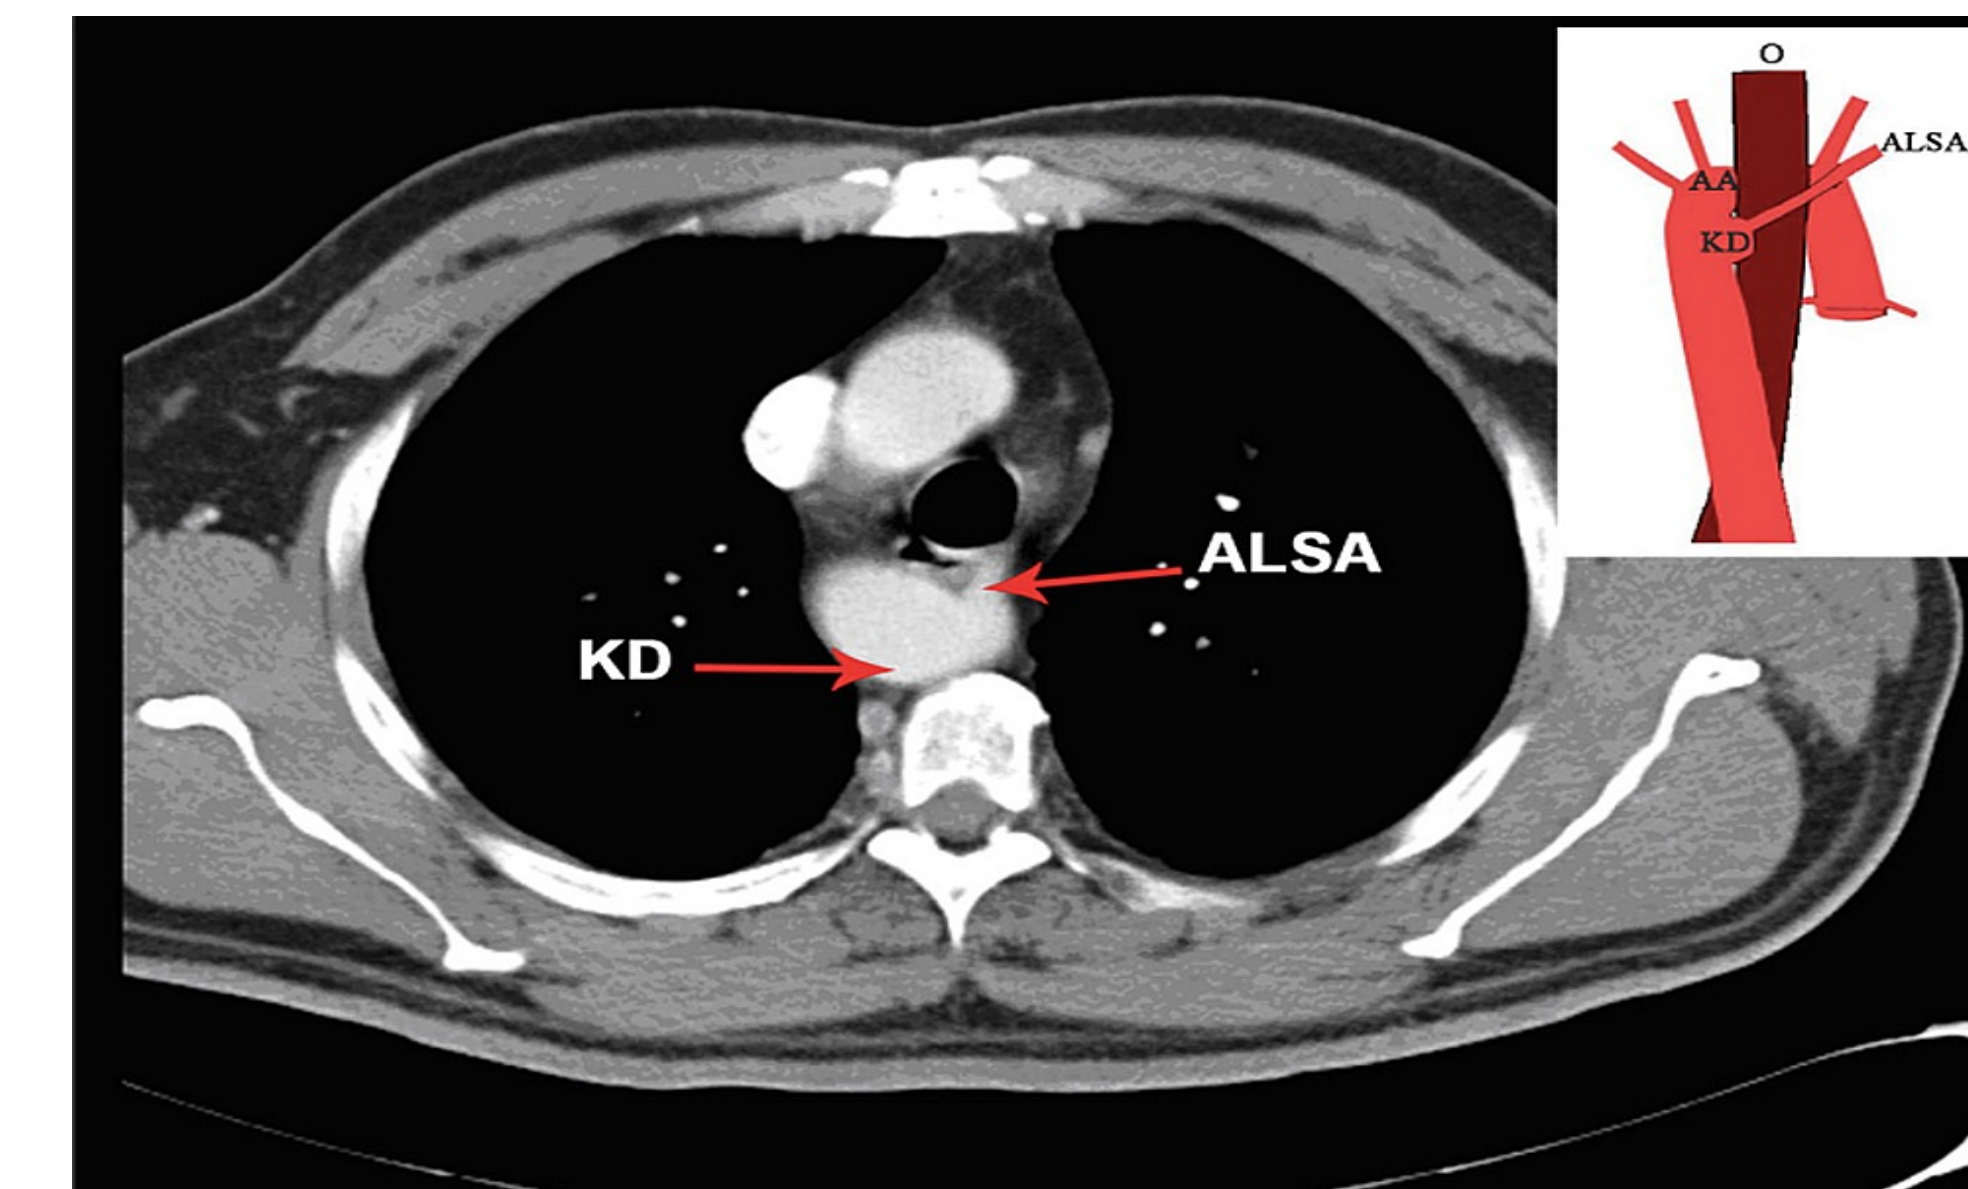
CT imaging of a patient with a Type 2 Kommerell Diverticulum.
